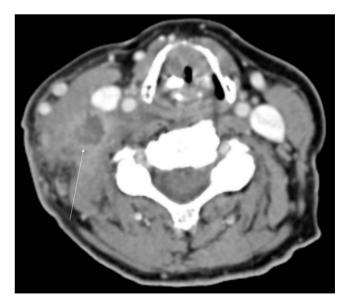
Axial contrast-enhanced CT showing a lowattenuation area with surrounding enhancing rim (white arrow) and surrounding inflammatory change consistent with an abscess in the lower neck.
